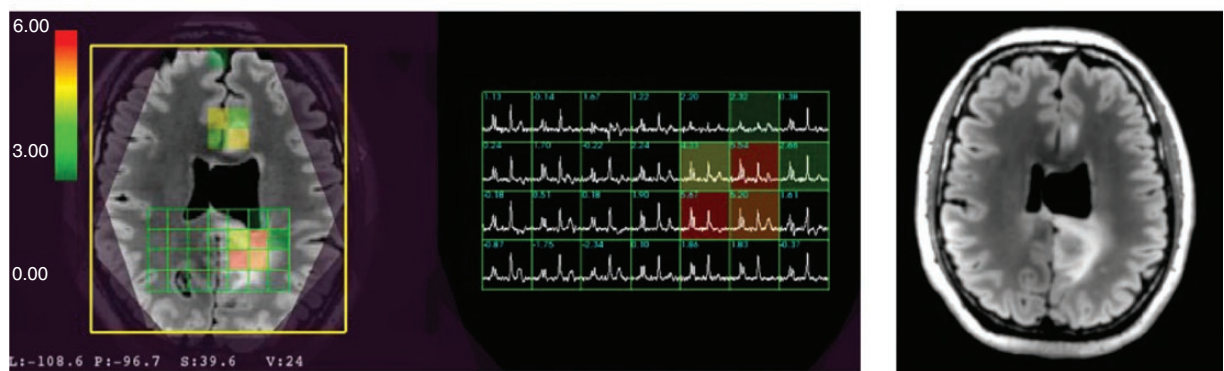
Example of 3D Lactate-edited 1H MRSI for a Progressed patient with LrGG at the time of (a) study enrollment and (b) progression. The Cho-to-NAA index (CNI) overlaid on T2 FLAIR weighted images shows that the extent of abnormal metabolic lesion has increased at the time of progression. The patient was a 48-year-old male with a grade 2 Astrocytoma, IDH-mutant.
